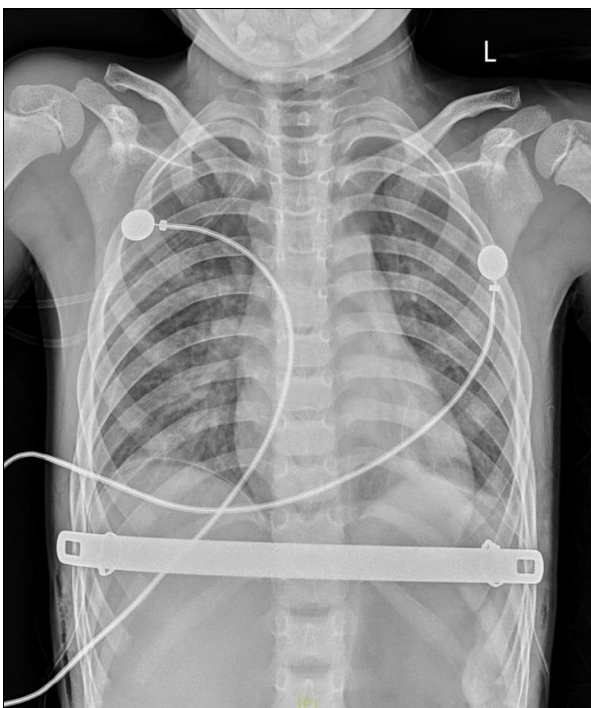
Postoperative X-ray examination showed the position and the fixation techniques of the steel bar
